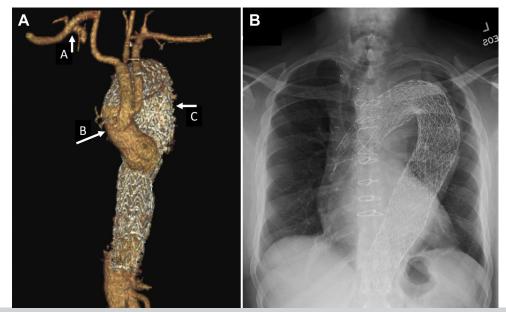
A, Postoperative computed tomography angiogram (CTA) demonstrating a patent right carotid artery to right subclavian artery bypass graft with interruption of the native aberrant right subclavian artery (*A*), a patent common bicarotid trunk and left subclavian artery debranching graft (*B*), and thoracic endovascular aortic repair (TEVAR) covering the aortic arch, aberrant right subclavian artery origin, and type B aortic dissection (TBAD) without evidence of endoleak (*C*). B, Upright chest radiograph demonstrating postoperative positioning of the TEVAR stent.
